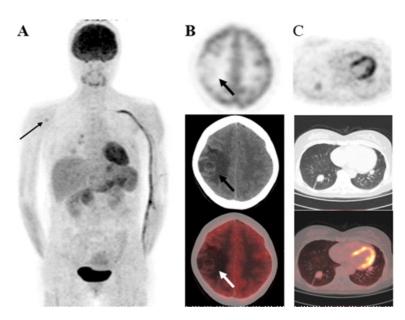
A 49-year-old woman with a history of radical resection of thyroid papillary carcinoma was admitted to hospital with headache a week ago. Laboratory tests showed that serum thyroglobulin (TG) (500ng/mL) was abnormally high. lodine-131 (¹³¹) whole-body scan was negative. For further evaluation, the patient underwent both fluorine-18-fluorodeoxyglucose (¹⁸F-FDG) and gallium-68 (⁶⁸Ga)-fibroblast activating protein inhibitor (FAPI) positron emission tomography/computed tomography (PET/CT) for the purpose of tumor staging. Maximum intensity projection (MIP) images of ¹⁸F-FDG PET showed mild tracer uptake in multiple lesions of the right lung. The MIP (A, long arrow), axial CT, and fusion ¹⁸F-FDG PET/CT images (not shown) showed bone destruction of the right shoulder joint increased ¹⁸F-FDG uptake. Axial views of ¹⁸F-FDG PET/CT (upper: PET image; middle: CT scan; lower: PET/CT fused image) showed no uptake of the right parietal lobe (B, solid arrow) which is a cystic low-density shadow with a large edema zone around it, and slight uptake of both lung lesions (C).
